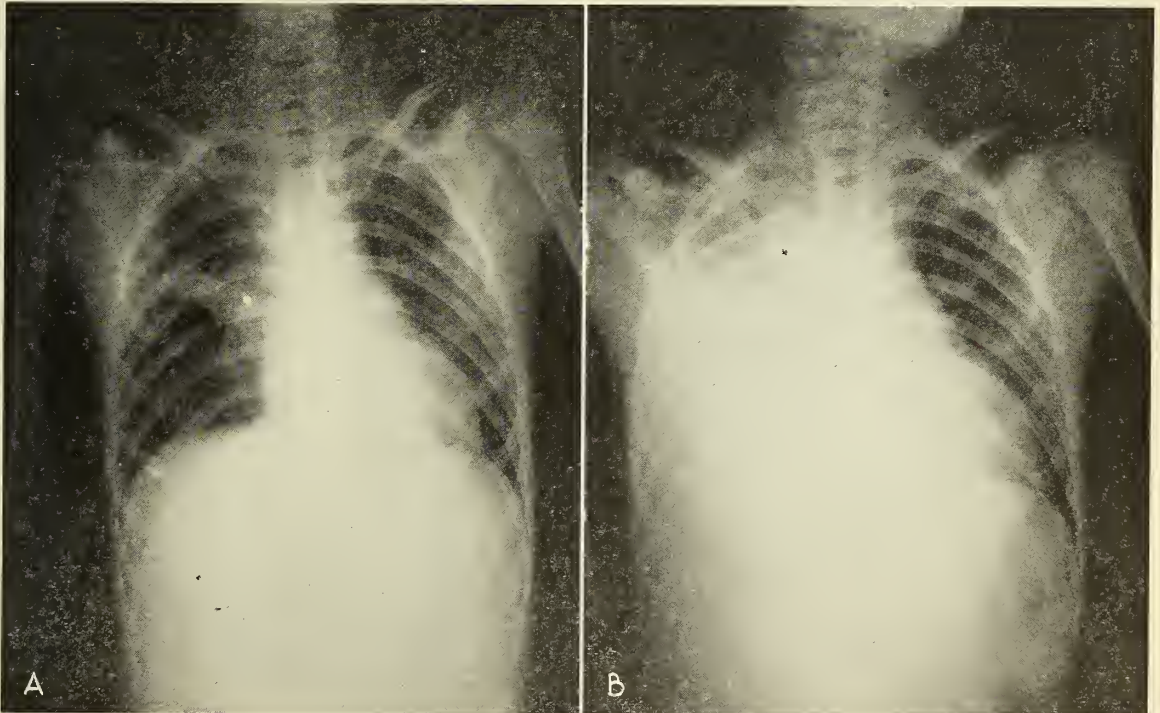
x-ray taken December 11, 1936; B, x-ray taken September 11, 1937.
